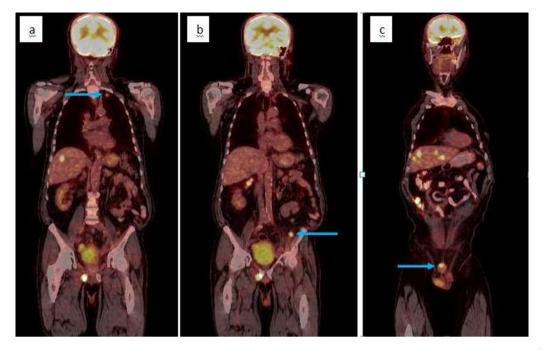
PET/CT Imaging(pre-chemotherapy). (a) The coronal 18FDG-PET/CT scans show, (arrow: left lung metastasis), SUVmax: 10.9. (b) The coronal ¹⁸FDG-PET/CT scans show, (arrow: pelvic lymph node metastasis), SUV_{max}: 9.9. (c) The coronal ¹⁸FDG-PET/CT scans show, (arrow: penile metastasis, 18 mm), SUV_{max}: 12.6.
